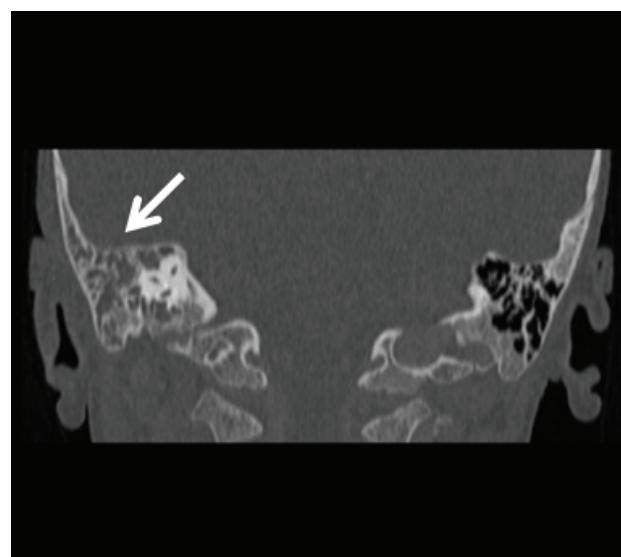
CT imaging of mastoiditis – frontal (own material)
